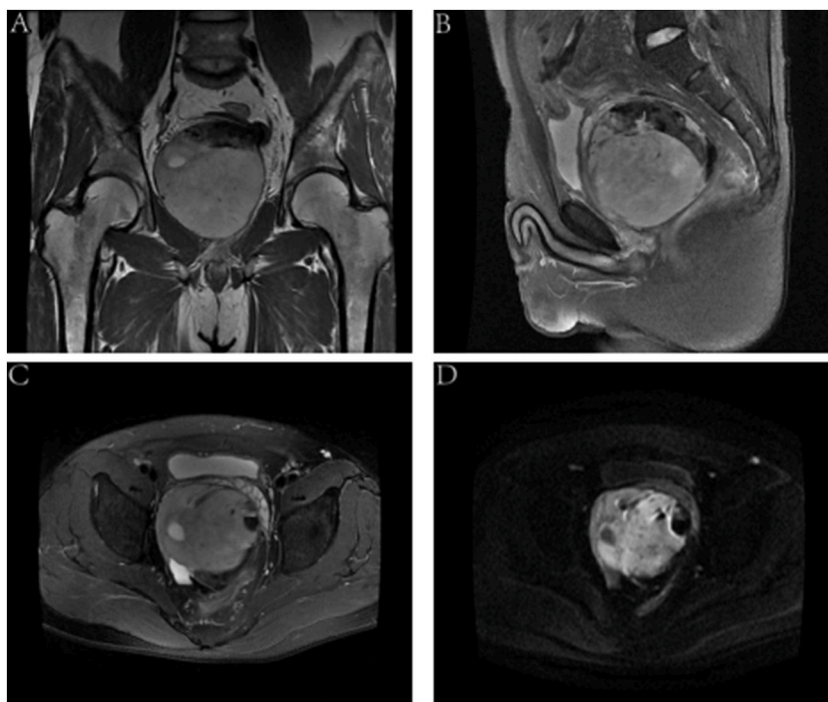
(A–C) Intrapelvic masses were observed in coronal, sagittal, and transverse views on T1 MRI sequences. (D) The coexistence of high, medium, and low signals on the magnetic resonance-diffusion weighted imaging (MR-DWI) sequence, namely, the "triple signal sign."
